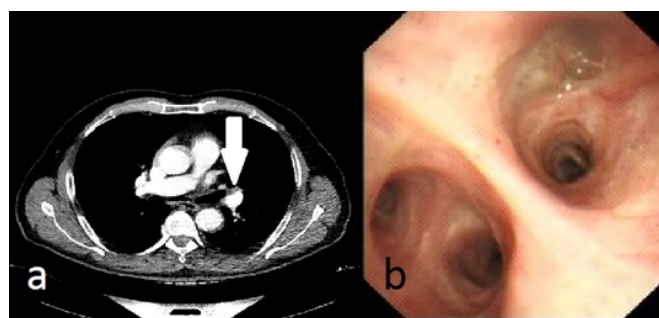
Preoperative thorax CT showing the primary endobronchial tumor (arrow) (a), bronchoscopic image showing the endobronchial tumor totally obstructing the left upper lobe bronchus but not extending to the lingular bronchus (b).
